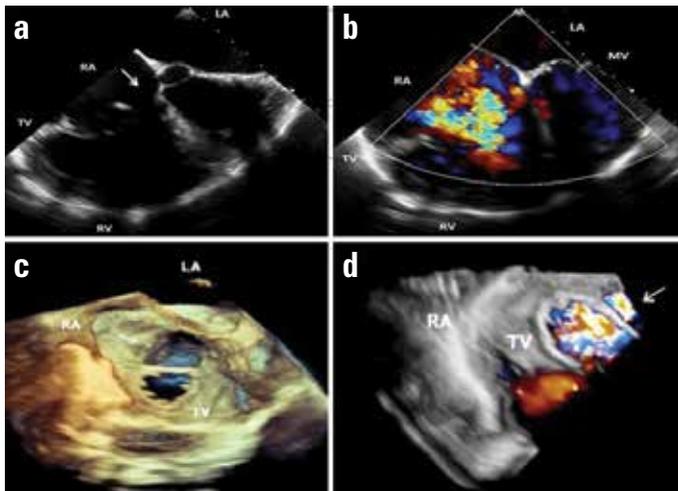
(a, b) Two-dimensional transesophageal echocardiography. (a) Four chamber view. Arrow points possible partial tricuspid valve ring annuloplasty detachment. LA, left atrium; RA, right atrium; RV, right ventricle; and TV, tricuspid valve. (b) Four chamber view with color Doppler showing severe tricuspid regurgitation. Mitral valve, MV. (c, d) Live/real time three-dimensional transesophageal echocardiography. (c) Arrow points partial tricuspid valve ring annuloplasty detachment from enface view. (d) Live/real time three-dimensional transesophageal echocardiography with color Doppler. Arrow points regurgitation from detached area
